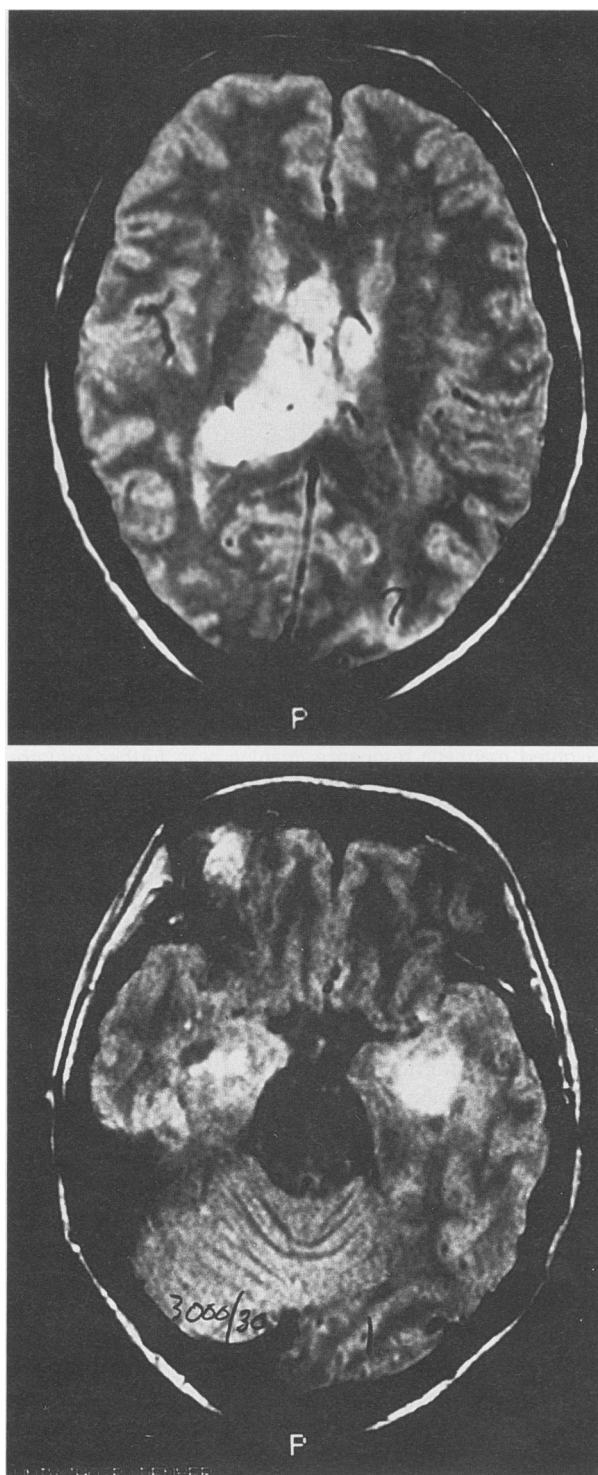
Temporolimbic tumor.* Patient 6 was manic for 3 months, and her age prompted this first echo T2-weighted magnetic resonance imaging scan showing bilateral medial temporal involvement with glioblastoma multiforme (TR = 3.0 sec, TE = 30 msec). Top, The tumor is shown in the fornical columns and right posterior temporal lobe. Bottom, More left-sided anterior temporal lobe involvement is shown. The patient died soon thereafter, and autopsy revealed diffuse infiltration of the temporal lobes, fornical columns, thalami, and hypothalami by glioblastoma multiforme.
